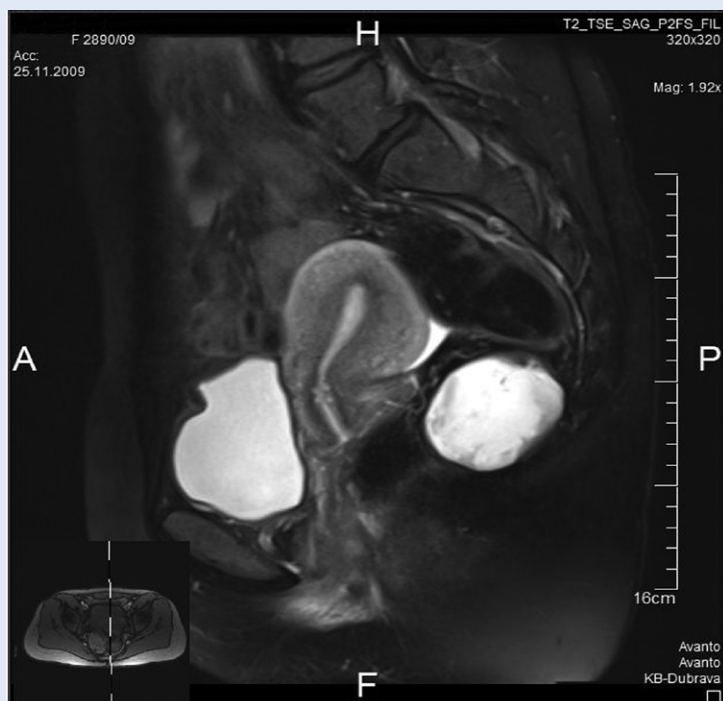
MRI T2W images: The tumor had heterogenous but mainly high signal intensity.
